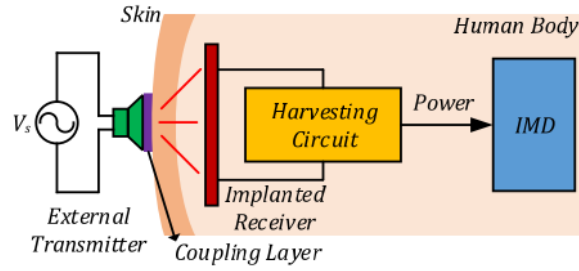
Example of an ultrasound power transfer. Taken from [71].
